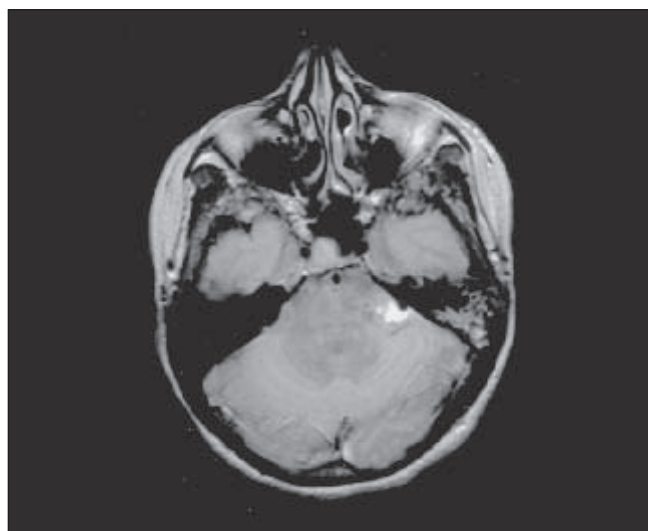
MRI (without contrast) showing the parasellar meningioma.
